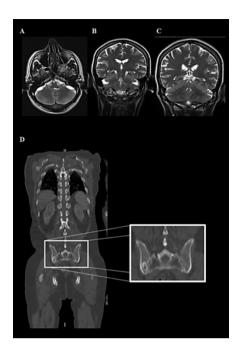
Brain magnetic resonance imaging (MRI) and thoracic-abdominopelvic computed tomography (CT). A Axial T2-weighted MRI scan showing an increased subarachnoid space. B, C Coronal T2-weighted MRI scans showing reduced bilateral cortical volumes, an increased space bilaterally at the cerebellopontine angle, and an increased subarachnoid space at the posterior cranial fossa. D Coronal CT reconstruction with an osteolytic lesion (22 × 13 mm) at the right iliac crest.
